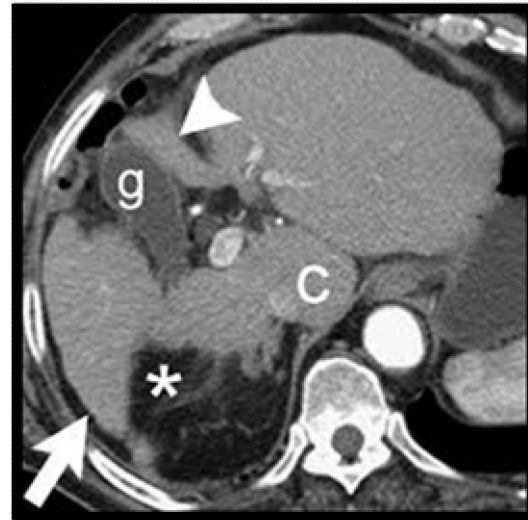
Typical cirrhotic morphology at axial enhanced CT image, showing enlarged caudate lobe (c), enlarged gall bladder fossa (g), medial segment atrophy of the left lobe (arrowhead) and right posterior hepatic lobe (arrow) and right posterior hepatic notch presence (asterisk)⁽²⁵⁾.
